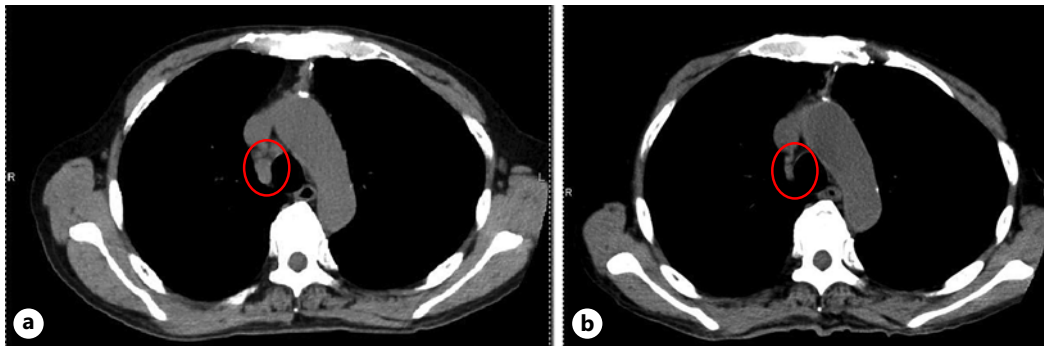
Comparison of computed tomographic images obtained before (a) and after (b) treatment showing a reduction in the size of mediastinal lymph nodes (red circles).
